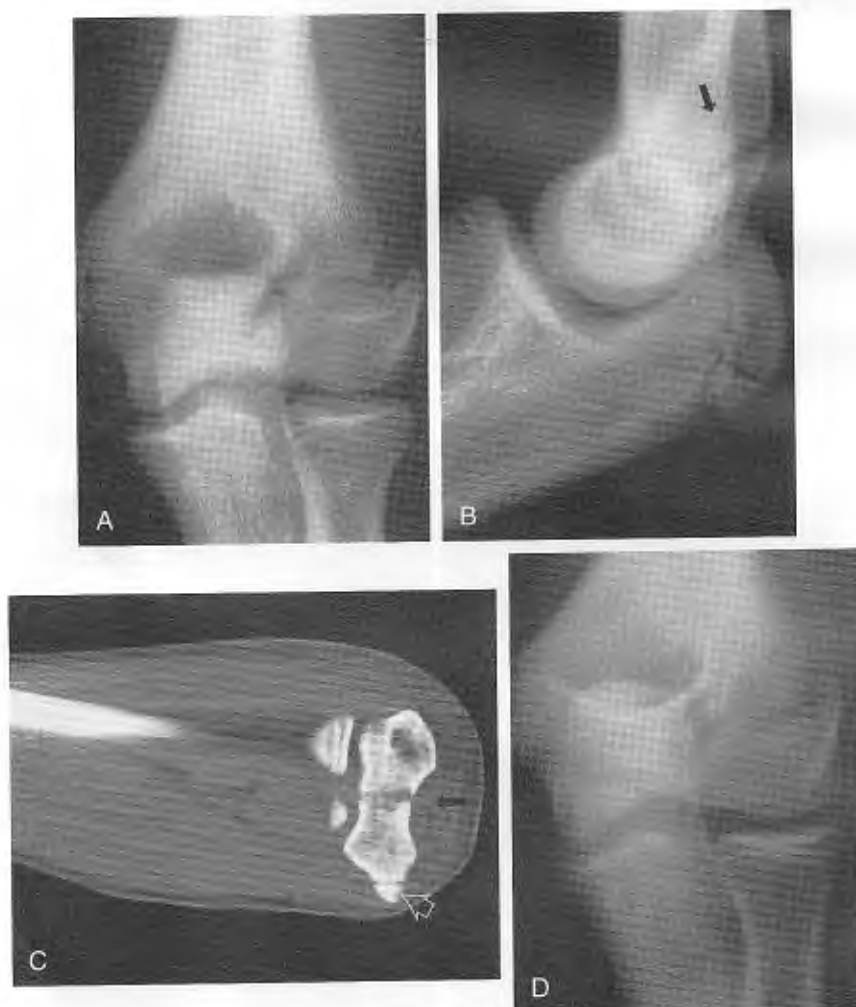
Salter type III lateral humerus fracture in a 14-year-old male athlete after coming down from a rebound during a basketball game. *A*, Anteroposterior view shows a possible displacement. *B*, Lateral view shows the fracture posteriorly (*arrow*). The open olecranon apophysis (*open arrow*) can also be seen. *C*, Computed tomography scan (*arrow*) showing the fracture centrally. Open arrow shows the normal medial humeral epicondyle; this was treated with cast immobilization and follow-up radiographs. *D*, Complete healing with no growth problem, and a normal follow-up examination.
